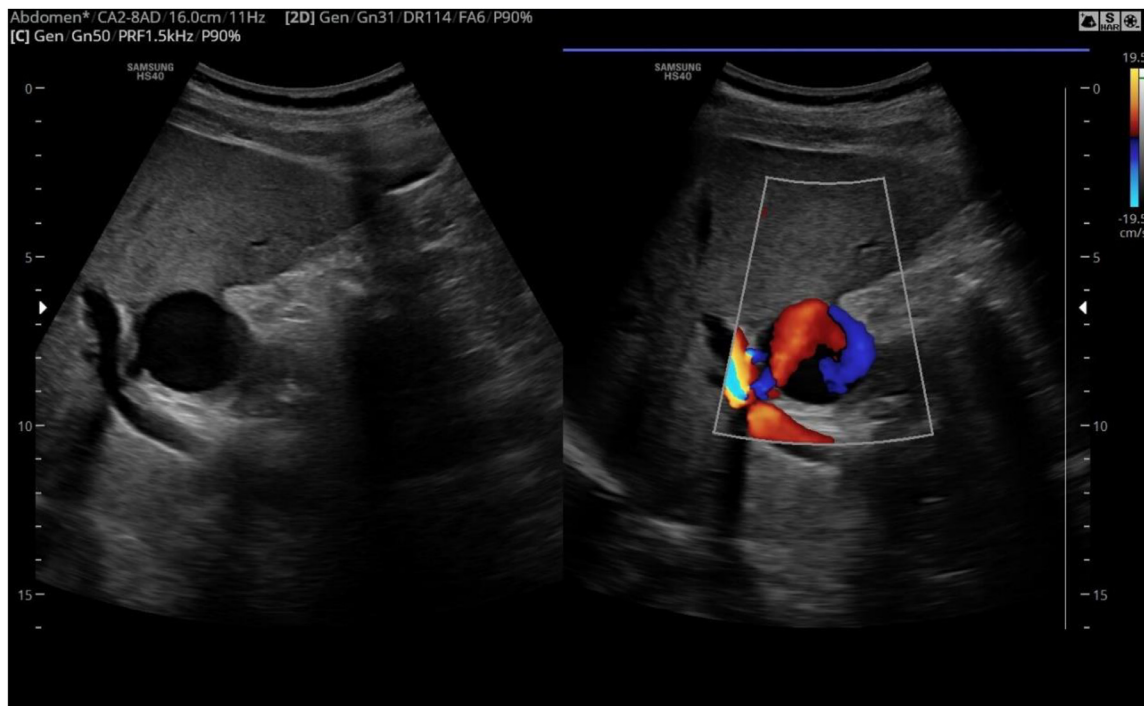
Duplex ultrasonography showing the hypoechoic round pseudoaneurysm arising from the hepatic artery at the porta hepatis, on B-mode. Corresponding color doppler image shows the characteristic "ying-yang" pattern of flow within the pseudoaneurysm.
